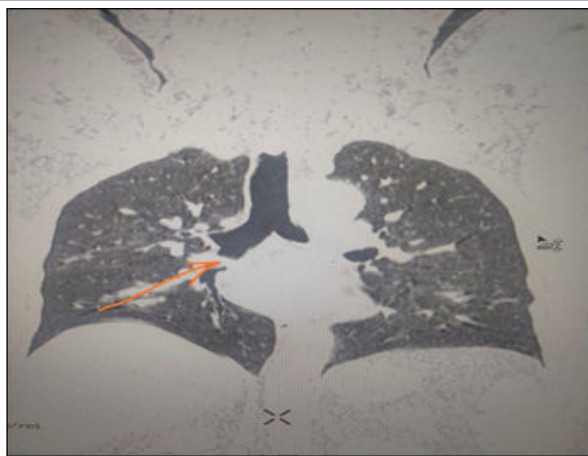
Patient's CT Scan Shows Foreign Body In Right Side Main Bronchus
